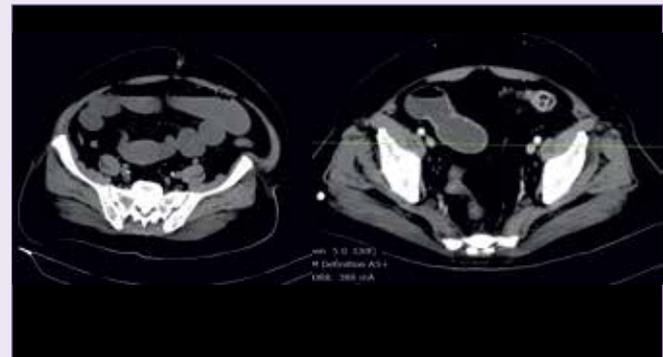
A) Initial CT and B) Followup CT show intestinal obstruction, gall stone with calcific specks and migration of gall stone from proximal to distal ileum in the follow-up CT after 4 days
